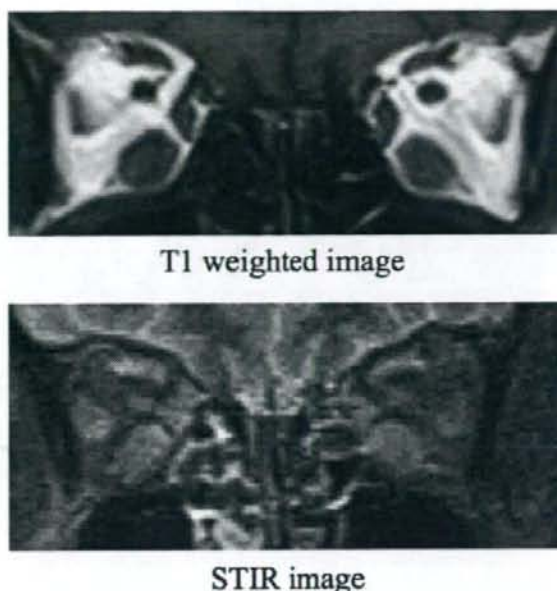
MRI of the orbits shows conspicuous enlargement of the bilateral inferior rectus muscles before steroid pulse therapy (coronal view).
